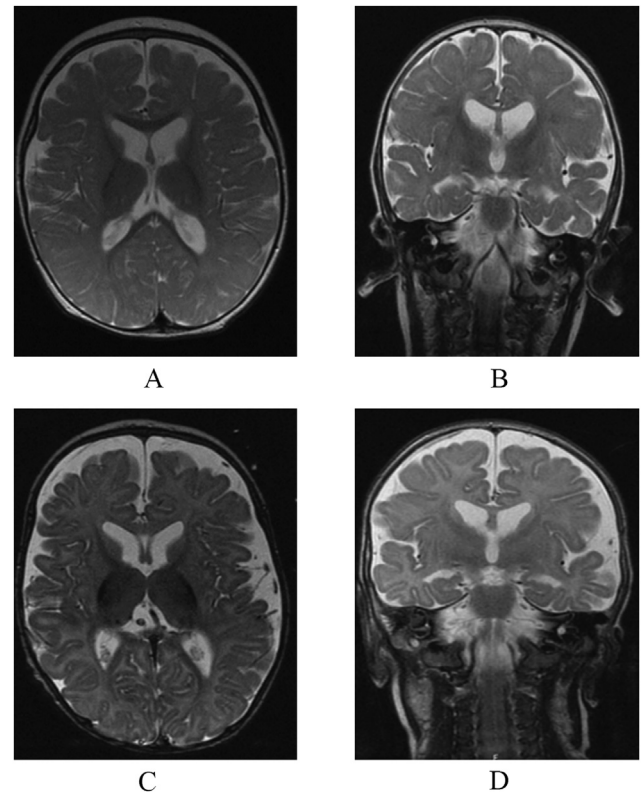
T2 axial weighted magnetic resonance imaging (MRI) showing hypomyelination and hypoplasia of basal ganglia. Prominent extra-axial CSF spaces more prominent frontal and temporal regions. 1A and 1B is an axial and coronal section of B1 at 10 months. 1C and 1D is an axial and coronal section of B2 at three and a half months.
